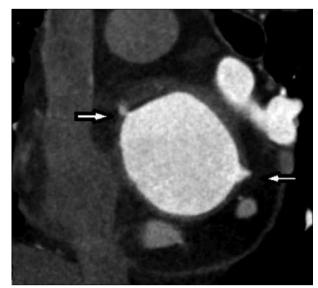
CT image shows two diverticula (*arrows*), with anterosuperior and lateral localizations, in the same patient.
